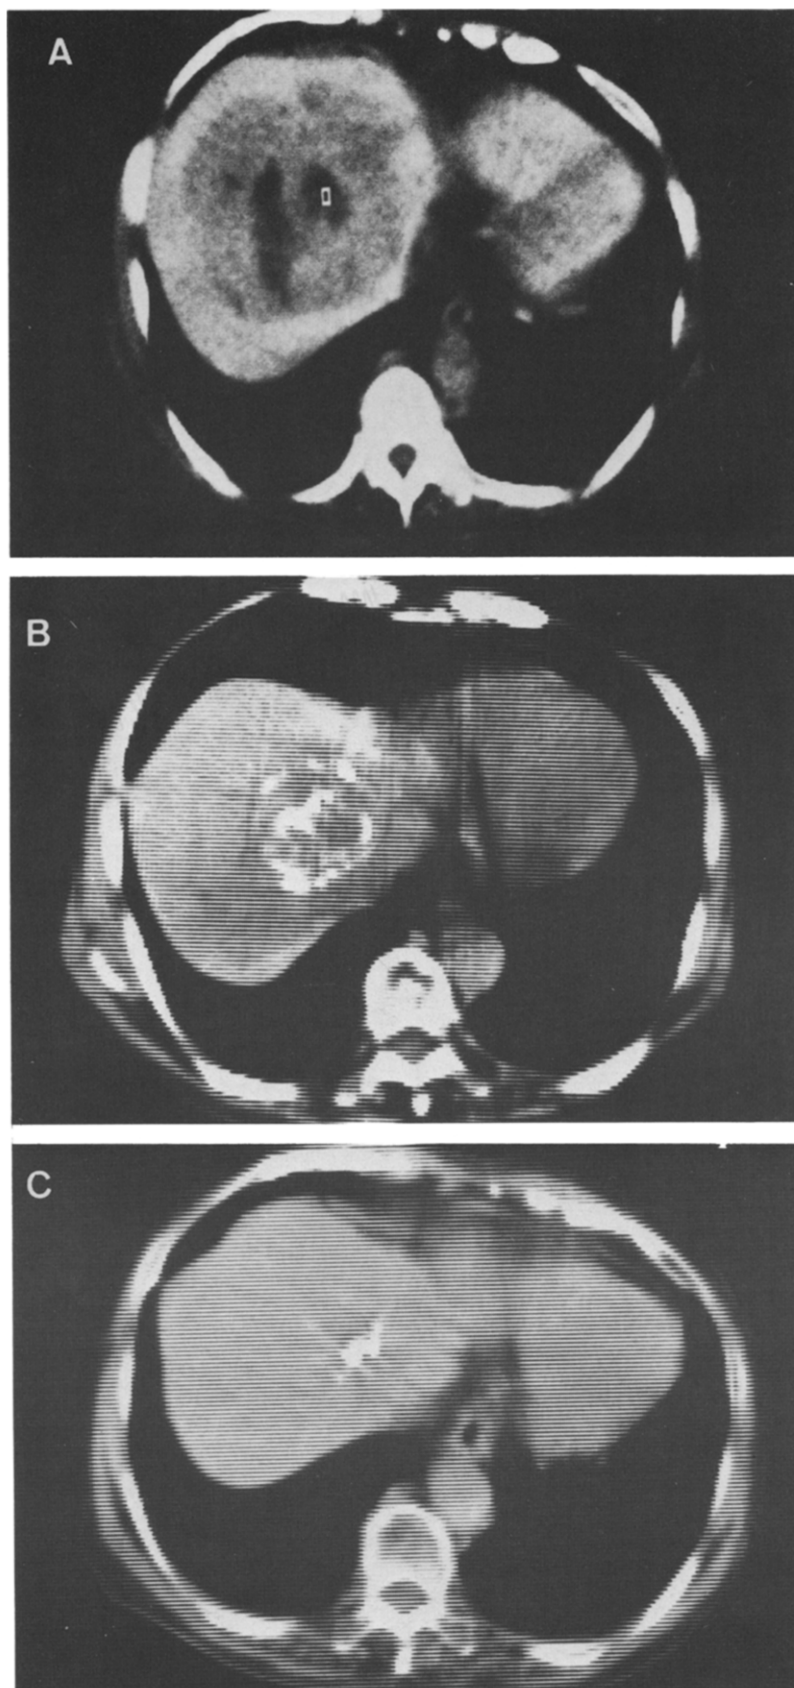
Demonstration of regression of hepatoma by CT (case 1). (A) Before administration of SMANCS ethiodol; (B) 4 months after administration; (C) 17 months after administration.
